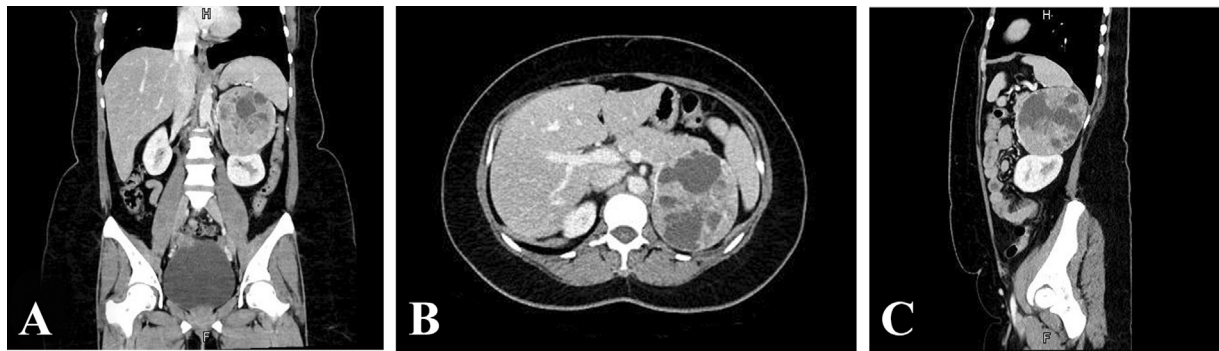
(A) Coronal, (B) transverse, and (C) sagittal sections of the computed tomography of the abdomen in the arterial phase of contrast enhancement. A large inhomogeneous lesion with cystic components can be seen in the left upper quadrant of the abdomen. The lesion abuts and compresses both the spleen and the upper pole of the left kidney (B and C). There is no evidence of local invasion, other masses, regional lymphadenopathy, or metastases to the parenchymal organs.
